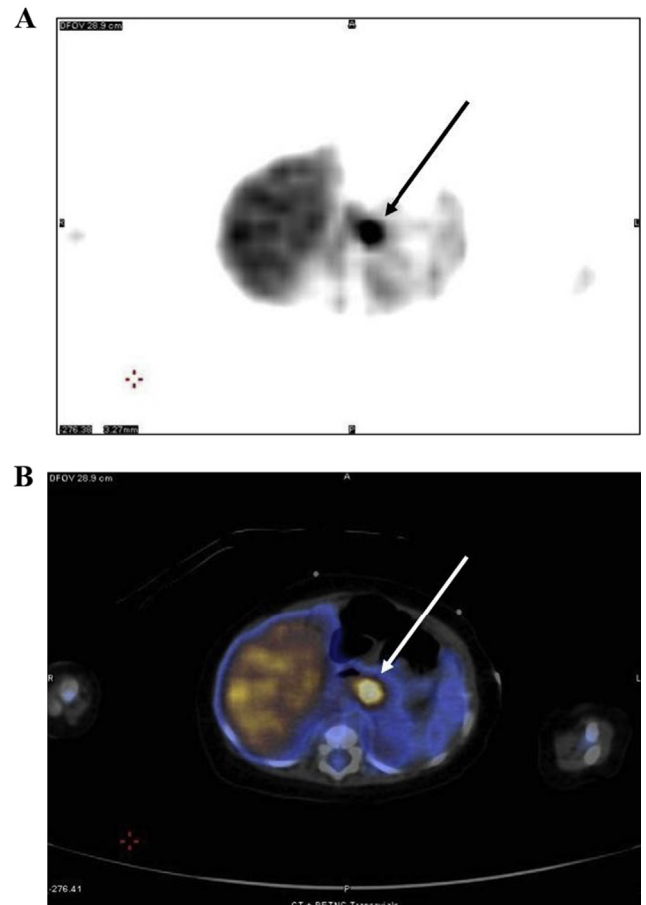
(A) Transverse view of a maximum intensity projection ^{18}F -DOPA PET image that demonstrates a focal lesion at the neck of the pancreas (black arrow). (B) Transverse view of the abdominal computed tomography + PET that revealed a bright enhancement near the neck of the pancreas (white arrow). ^{18}F -DOPA PET = 18-fluoro L-3,4-dihydroxyphenylalanine positron emission tomography; PET = positron emission tomography.
